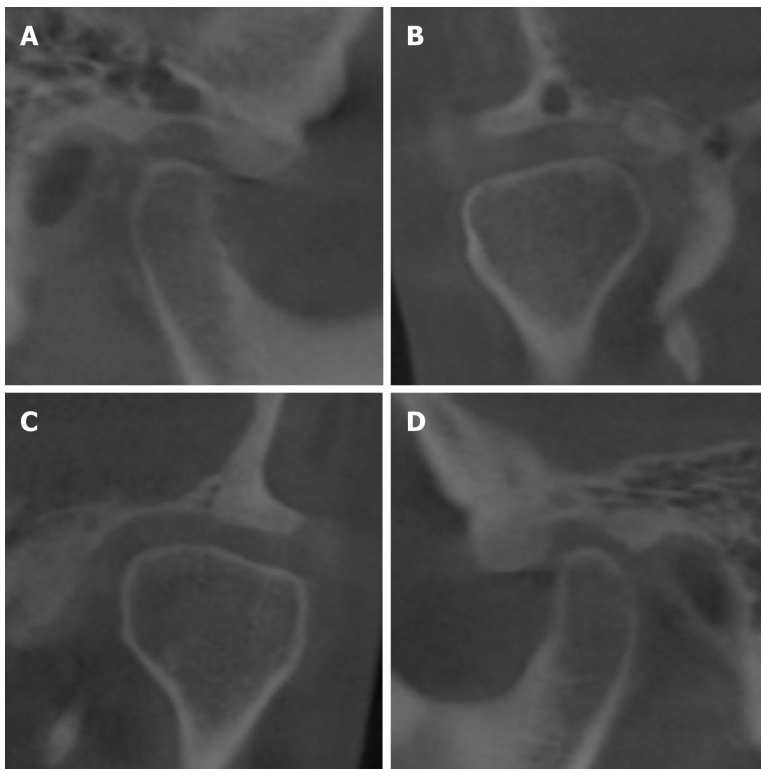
Seven-year follow-up cone-beam computed tomography images indicating no change when compared with the previous images.
